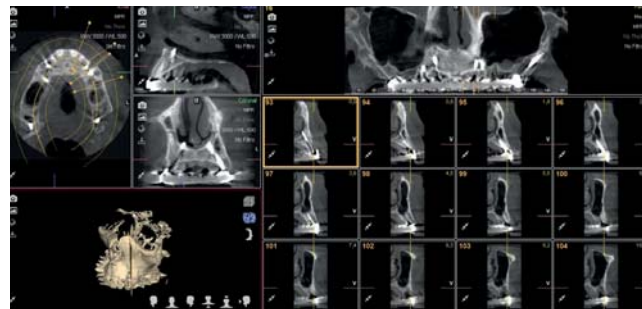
CT-Slides showing in the anterior part the anchorage of the implants BCS® in the second cortical.
